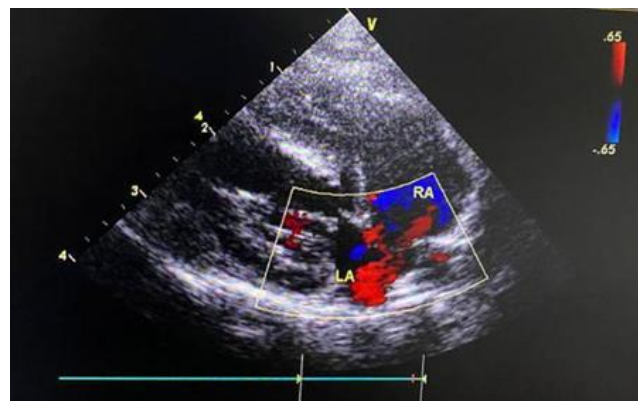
Color Doppler Imaging in right parasternal long axis view of ASD with left to right shunting
